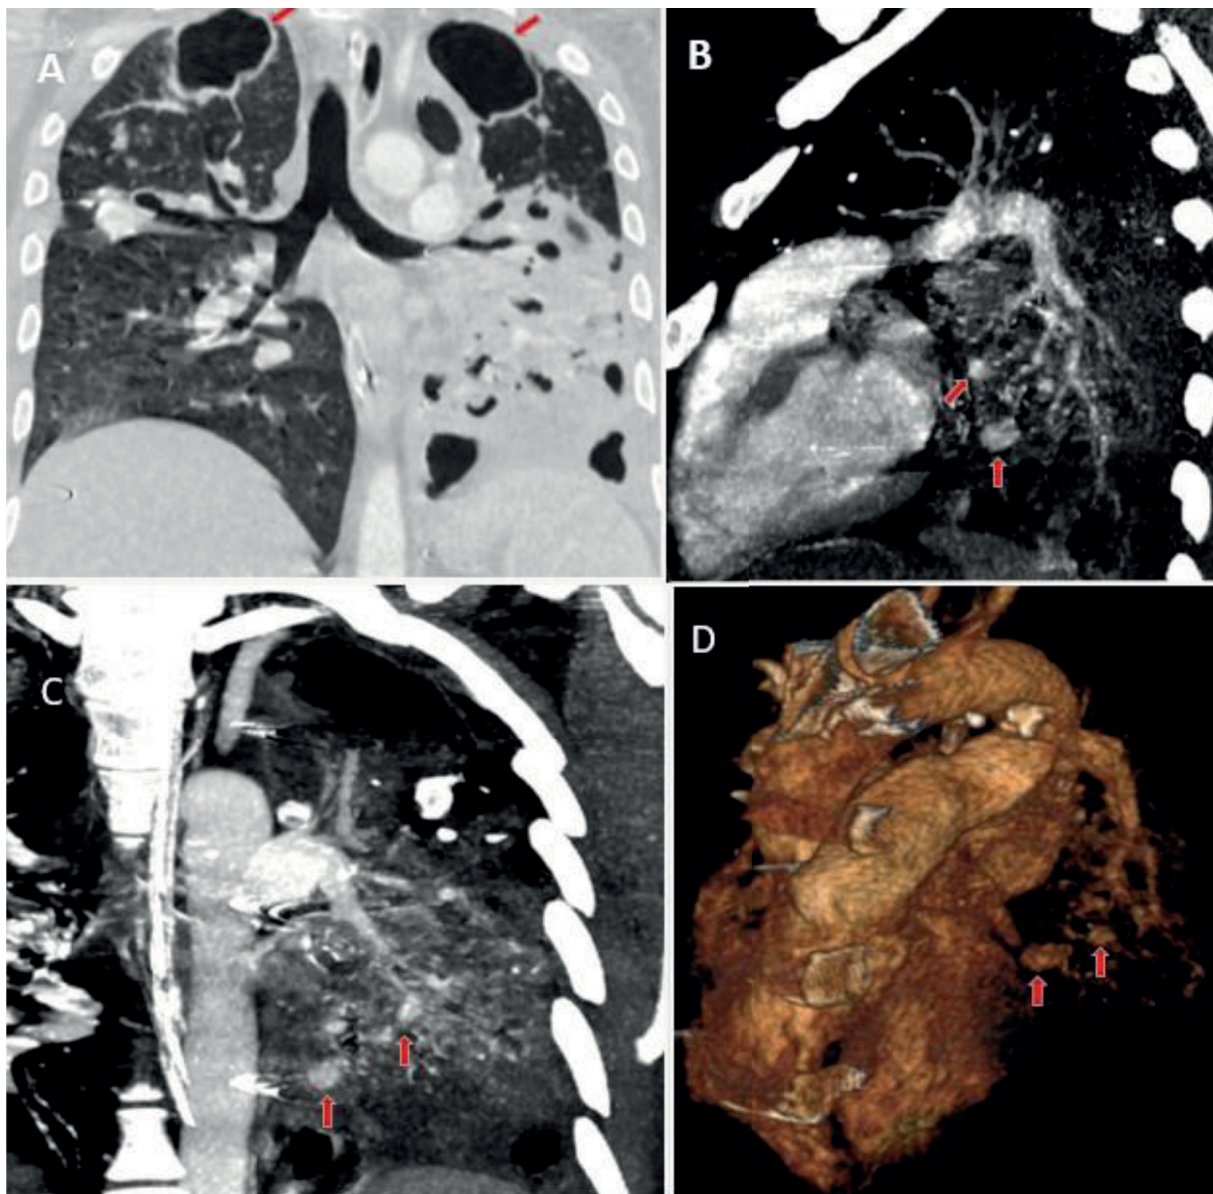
Chest CT angiography (CTA). Lung window (A) showing cavitations in bilateral upper lobes (red arrows) with destroyed lingula and left lower lobe. Maximum intensity projection (MIP) sagittal (B), coronal (C) and 3D virtual (D) reconstructions showing contrast filled outpouchings (red arrows) arising from branches of left pulmonary artery.
